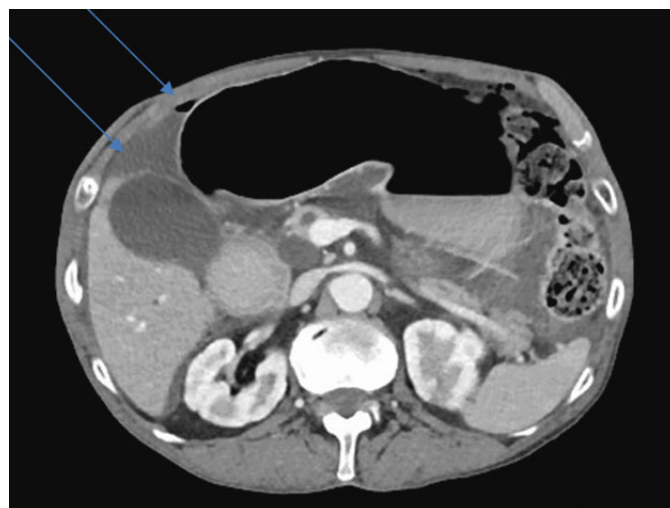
Coronal section of computed tomography scan shows intra abdominal free fluid and free air.
